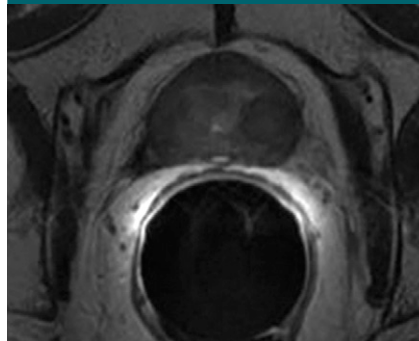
Transverse T2-weighted MR image in 78-year-old man who has undergone external-beam RT shows decreased signal intensity throughout prostate, with loss of zonal differentiation.
